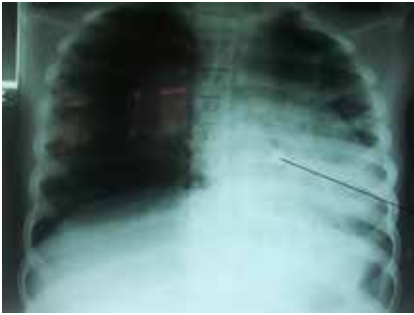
Post-operation X-ray after the first bronchoscopy. The foreign body (arrowed) is more visible in the distal end of the left main bronchus; despite the failed attempt there is evidence of better left upper lobe aeration compared to the pre-admission image.
